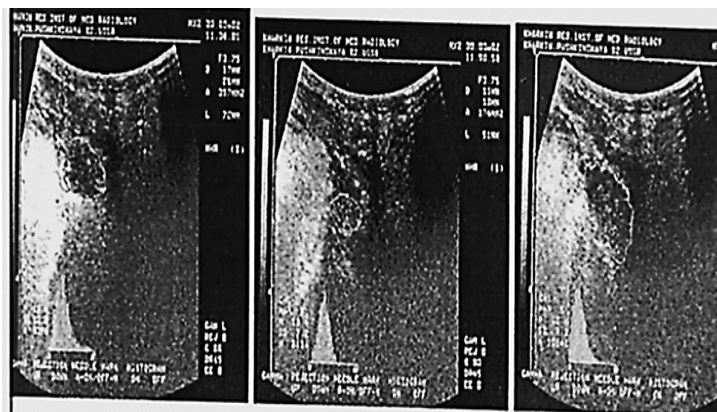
Ultrasound scanning of a hypertrophied lingual tonsil before cryosurgical intervention, at the time of intervention and 11 minutes after cryotherapy
